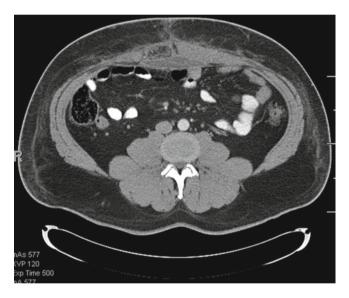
Fluid collection between the reapproximated anterior abdominal wall and the biologic prosthesis placed in the retrorectus position. CT-guided drainage can be performed to evacuate the collection if symptomatic
